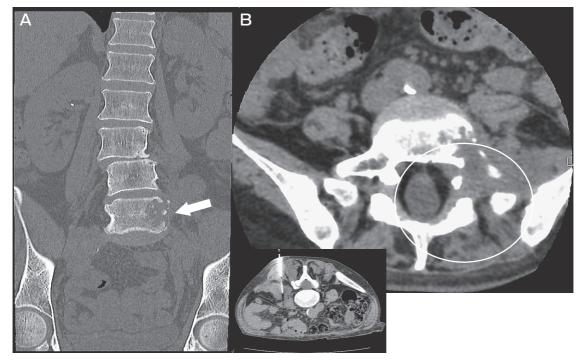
A, X-ray of the spine showed bone destruction in the left fifth vertebral body (⇒); B, Computed tomography of the abdomen showed abscess in the left fifth vertebral body (○).
